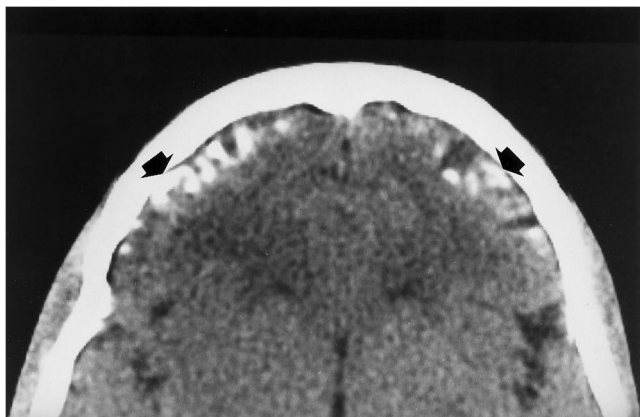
Case 2. Noncontrast CT scan shows frontal cortical calcifications (arrows) and atrophy. At the time of the imaging study, at the age of 21 years, the patient had no neurologic signs or symptoms.
